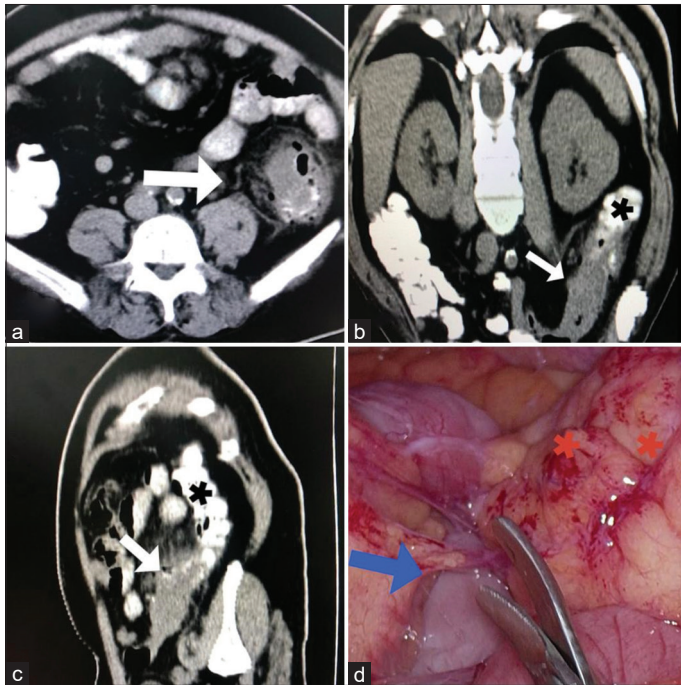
(a) CECT axial section shows affected sigmoid colon (white arrow), (b) CECT slanting axial view shows strictured sigmoid colon (white arrow) with normal contrast filled proximal colon (black asterisk), (c) CECT sagittal view with same findings as B, (d) Lysis of mesenteric adhesions (blue arrow) with the affected sigmoid colon (orange asterisks). CECT: Contrast-enhanced computed tomography
